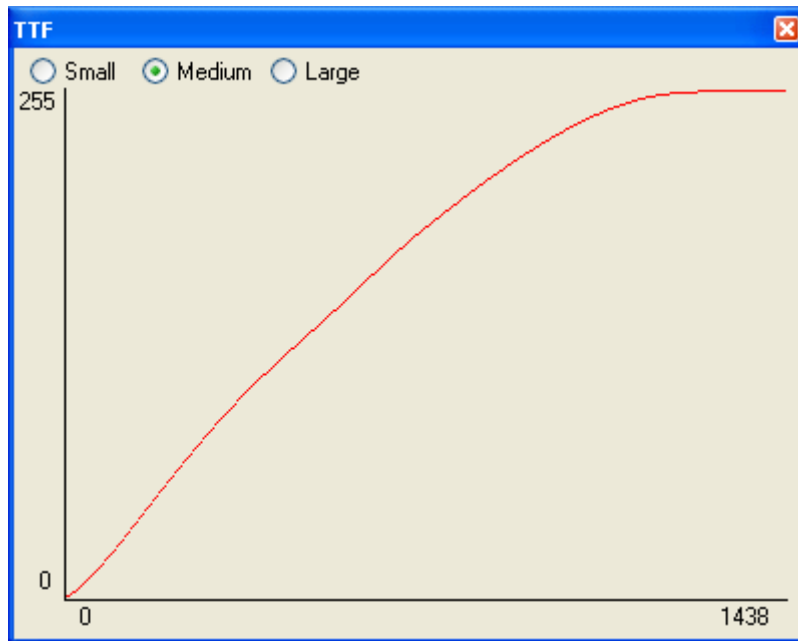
The tone transfer function used to map the original 1439 intensities in the MRI data set shown in Figure 1 to the 256 intensities that can be shown by a standard CRT or LCD monitor.
